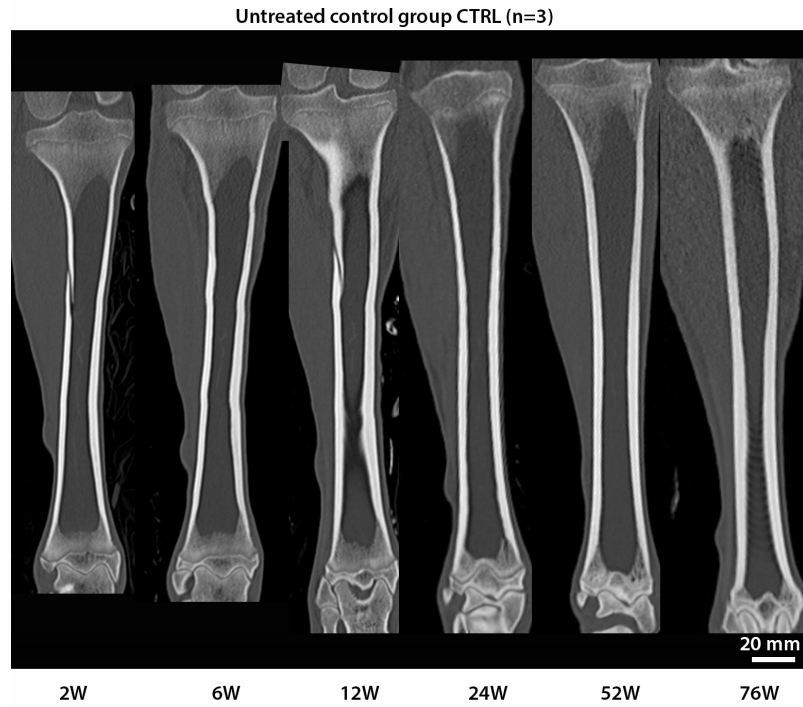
Clinical CT imaging of untreated control CTRL from week 2 to week 76.
